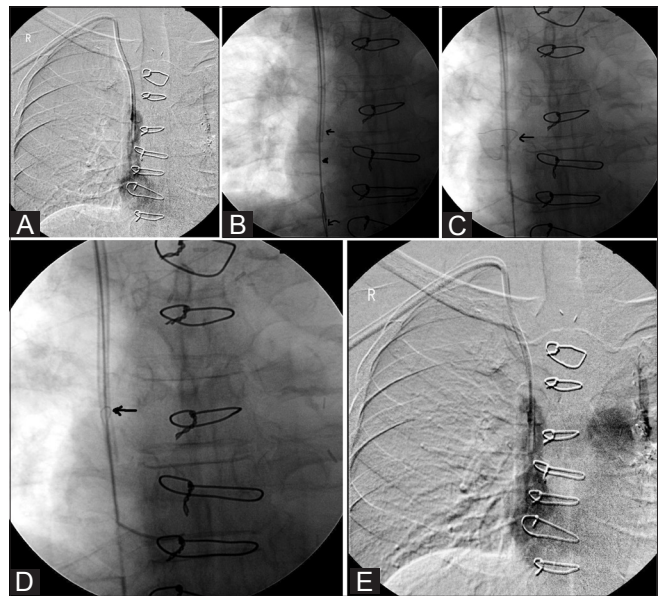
(A-I): A 54-year-old man with right IJV thrombosis causing SVC syndrome. Venogram (A) shows complete occlusion of the right IJV (arrow), with draining collaterals (arrow head). Recanalization venograms (B,C) show an irregular filling defect in the SVC (arrow) and a tight web at the cavo-atrial junction (curved arrow in C). Sequential balloon plasty of the right IJV and SVC (arrow) is seen (D-F). Venogram (G) shows restoration of the lumen, with SVC stenting done due to elastic recoil (arrow). Persistent brachiocephalic recoil (arrowhead) is seen. Frontal spot radiographs (H,I) show good restoration of the lumen, poststenting balloon remodeling (arrowhead), with the SVC stent in situ (arrow)
